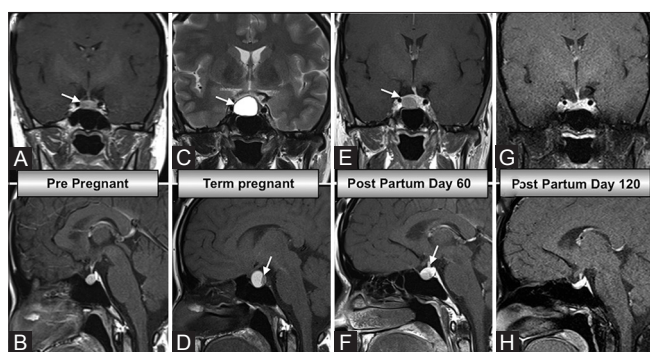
T1-weighted contrast-enhanced magnetic resonance imaging (Panels A [coronal] and B [sagittal]) showed a 4 mm hypointense lesion on the right side of the pituitary (arrow), T2-weighted noncontrast magnetic resonance imaging demonstrated a hyperintense lesion with a fluid level in an enlarged sella (Panels C and D), consistent with pituitary apoplexy. T1-weighted contrast-enhanced magnetic resonance imaging at 2-month postdelivery with resolution of apoplexy and persistence of the underlying adenoma (Panels E and F arrows). T1-weighted contrast-enhanced magnetic resonance imaging at 4-month postpartum revealed complete resolution of the pituitary adenoma (Panels G and H)
